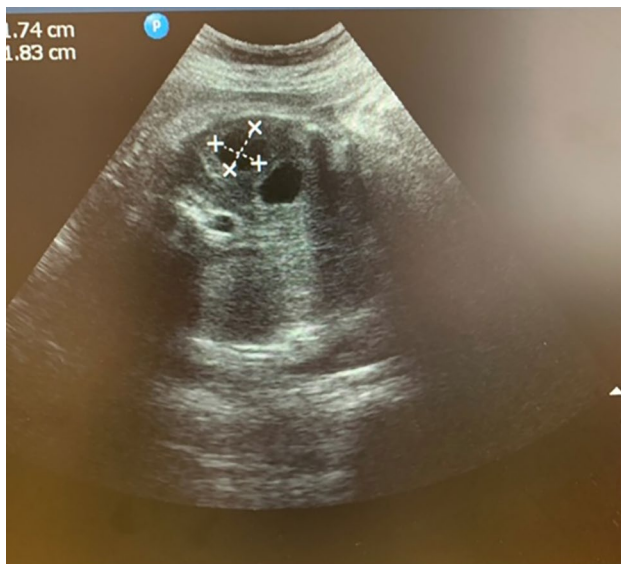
Ultrasound of the fetal left upper abdomen at 34 weeks showing a single cystic mass within the spleen
